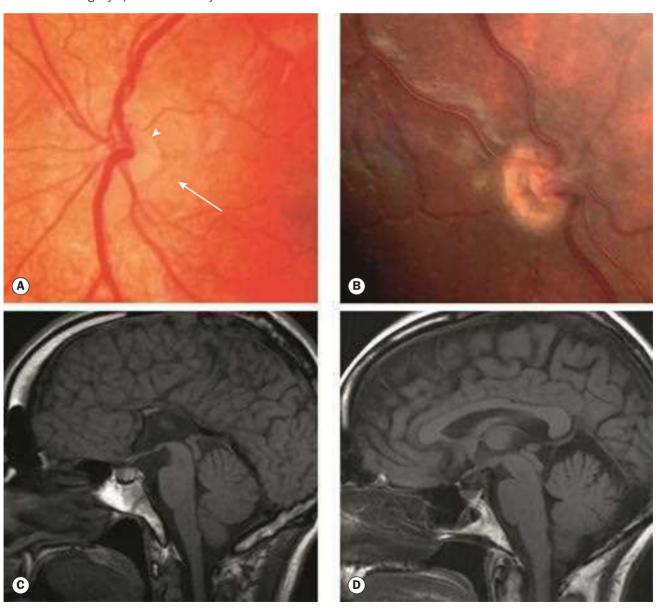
(A) Moderately hypoplastic disc showing the double-ring sign. The arrowhead shows the edge of the disc and the arrow shows the edge of visible sclera; (B) markedly hypoplastic disc; (C) midline sagittal T1-weighted MR image demonstrating agenesis of the corpus callosum while (D) demonstrates a normal corpus callosum (*Courtesy of D Hildebrand – fig. A; A Moore – fig. B*)
